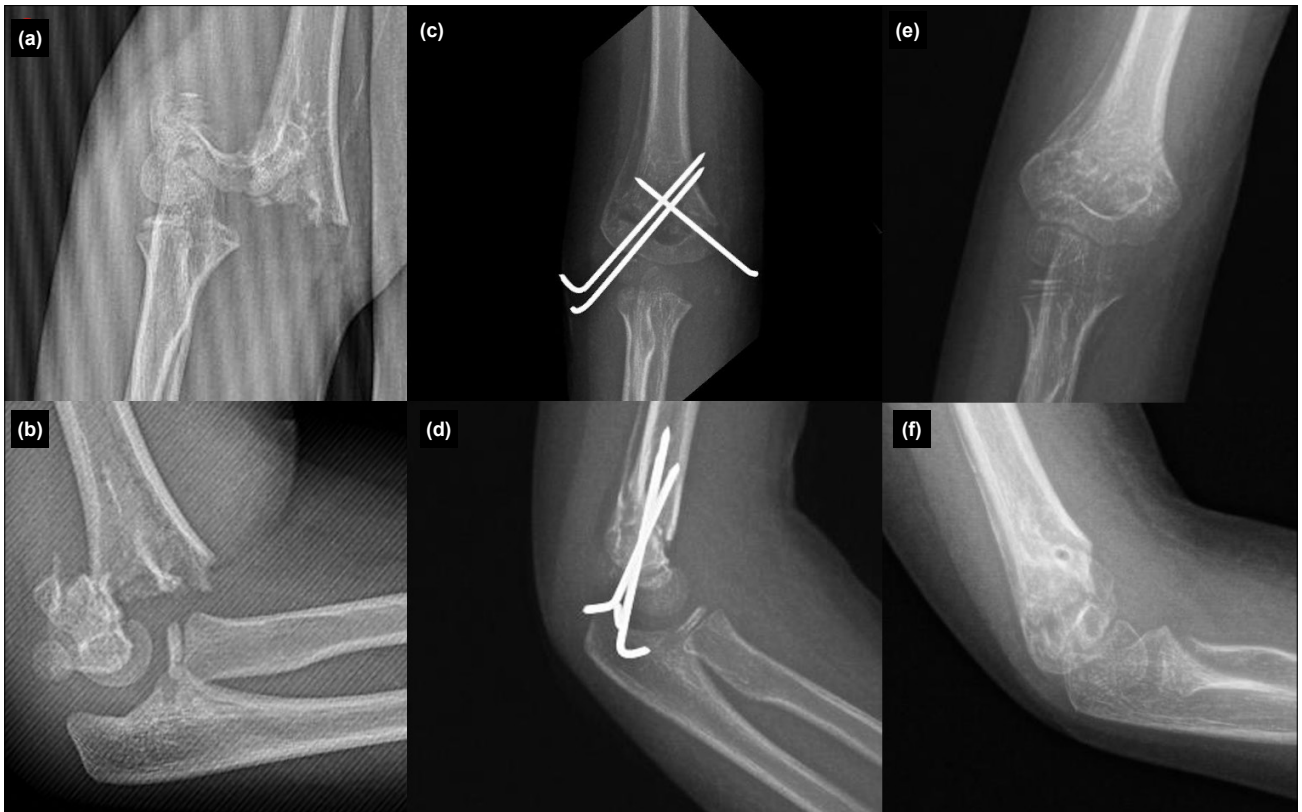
Preoperative, postoperative, and follow-up anteroposterior and lateral radiographs of a patient who underwent surgery using the medial-first approach.
